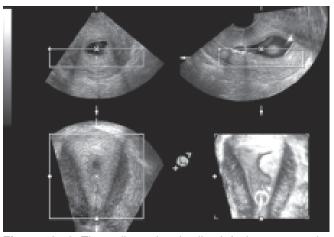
Three-dimensional saline infusion sonography of an endometrial polyp protruding into the uterine cavity (lower right image)
